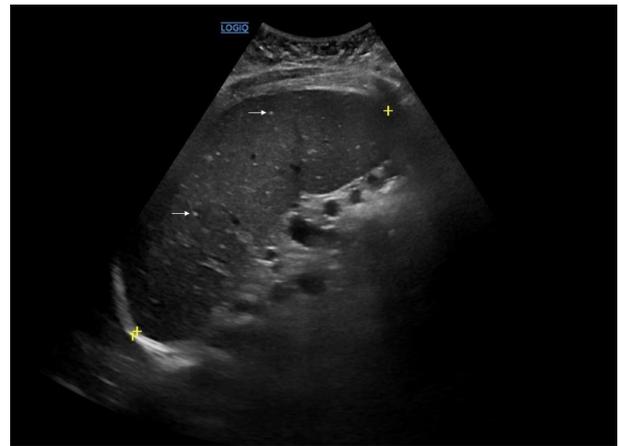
Abdominal ultrasound revealed the presence of multiple hyperechoic spots (two of them highlighted with arrows) dispersed within a large spleen (with a diameter of 19 cm).
